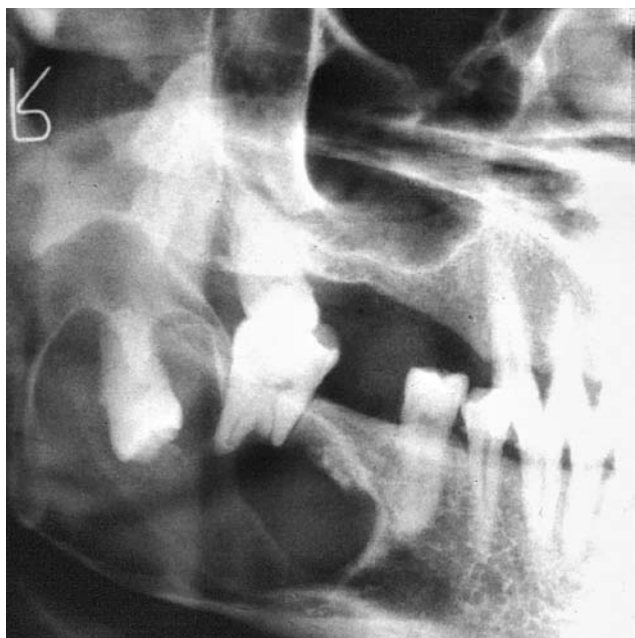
Radiograph of a circumferential type dentigerous cyst associated with a mandibular third molar. The tooth of origin is displaced and the cyst wall has resorbed part of the root of the adjacent molar.
